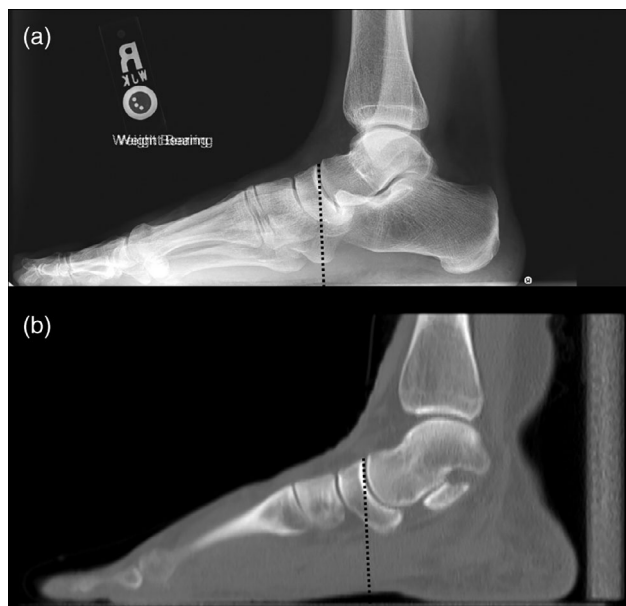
Navicular height, represented by the dotted black on weight-bearing radiograph (a) and solid white lines on a SWCT (b), for the same participant
